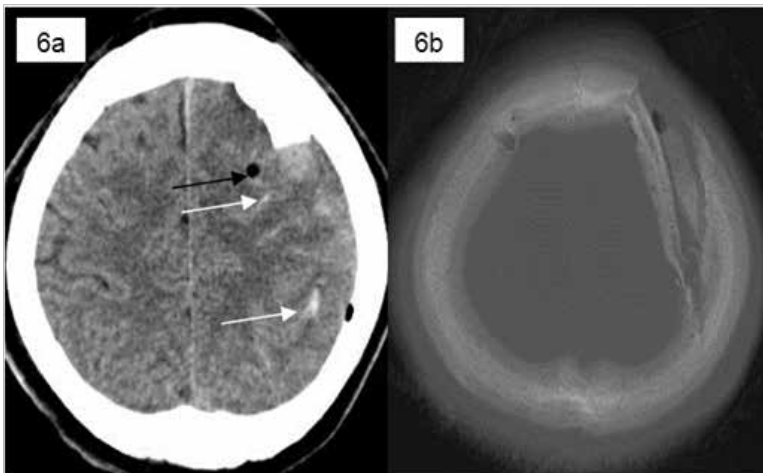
Axial CT scan brain window (6a) and bone window (6b).
